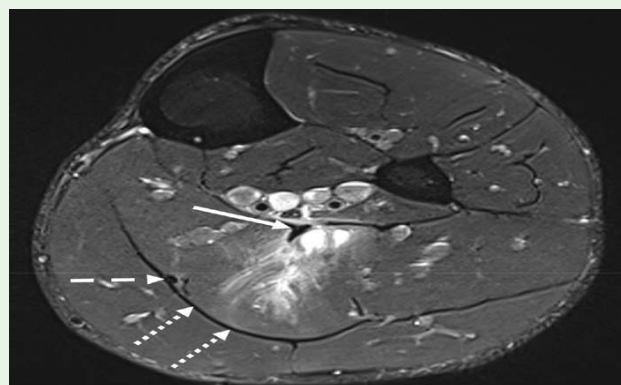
34-year-old elite national ARF player with recurrent medial intra-muscular aponeurosis tear. a Axial T2-FS MRI of the left calf showing recurrent tear at a medial intra-muscular aponeurosis scar (arrow). Feathery fluid signal is seen extending towards a thickened medial posterior soleus aponeurosis (dotted arrows) and plantaris tendon (dashed arrow) with adjacent scarring. The player did not require adhesiolysis.
